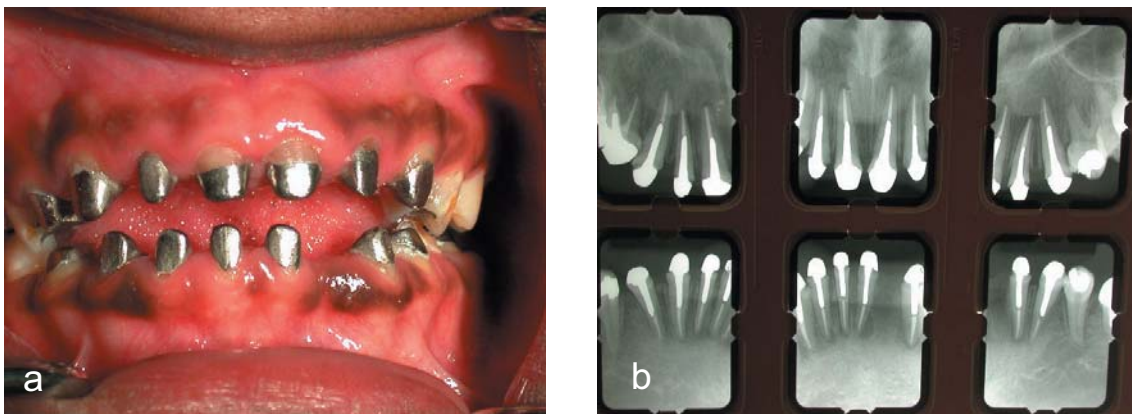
(a) Post and cores cemented in upper and lower arches. (b) Radiographs of post and core.
